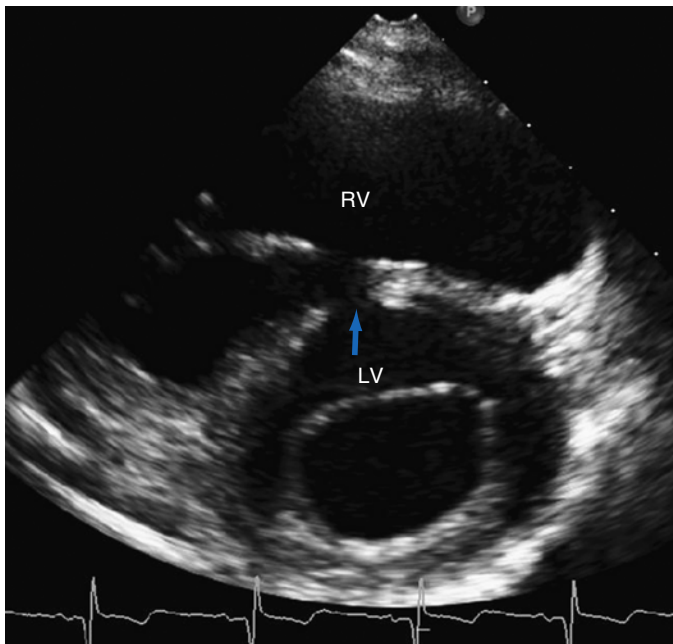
Two-dimensional transthoracic echocardiography (2D TTE) from parasternal short axis view showing a muscular trabecular ventricular septal defect (VSD) (blue arrow). LV, Left ventricle; RV, right ventricle.
